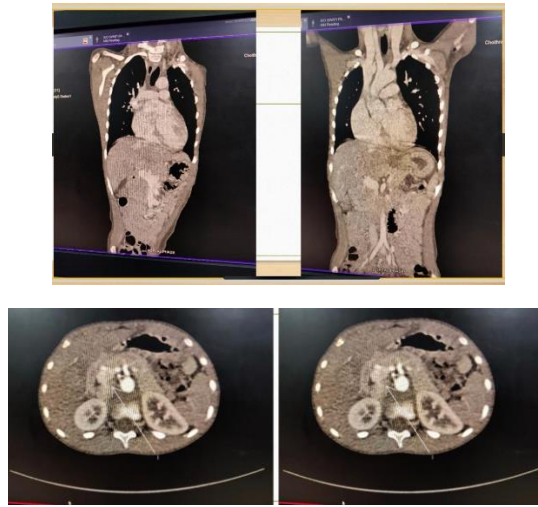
CT pulmonary and abdomen angiography
